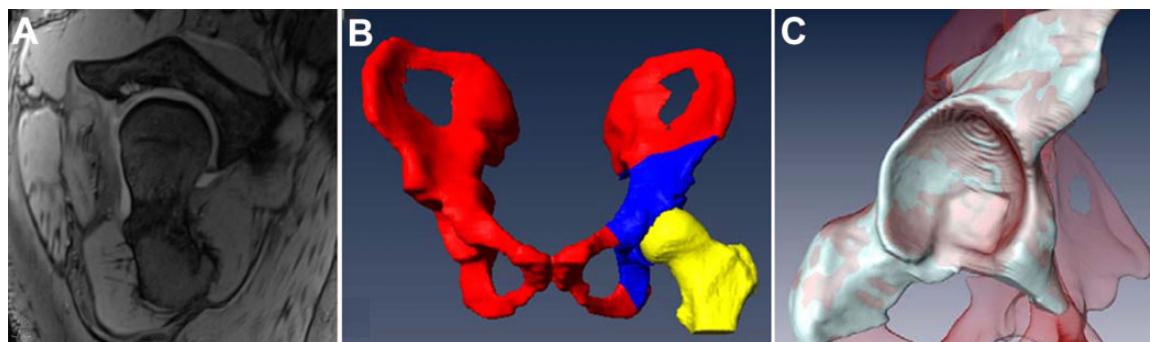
(A) The high-resolution unilateral 3D MRI scan of the T1 volumetric interpolated breath-hold examination sequence and (B) the MRI-based 3D model are shown. (C) An acetabular MRI-based 3D model (white) and a CT-based 3D model (red transparent) are shown to calculate accuracy.
